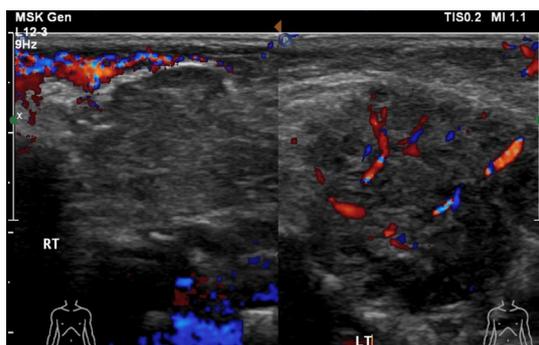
Sonographic images showing increased vascularity within the left parotid gland in comparison to the right.
